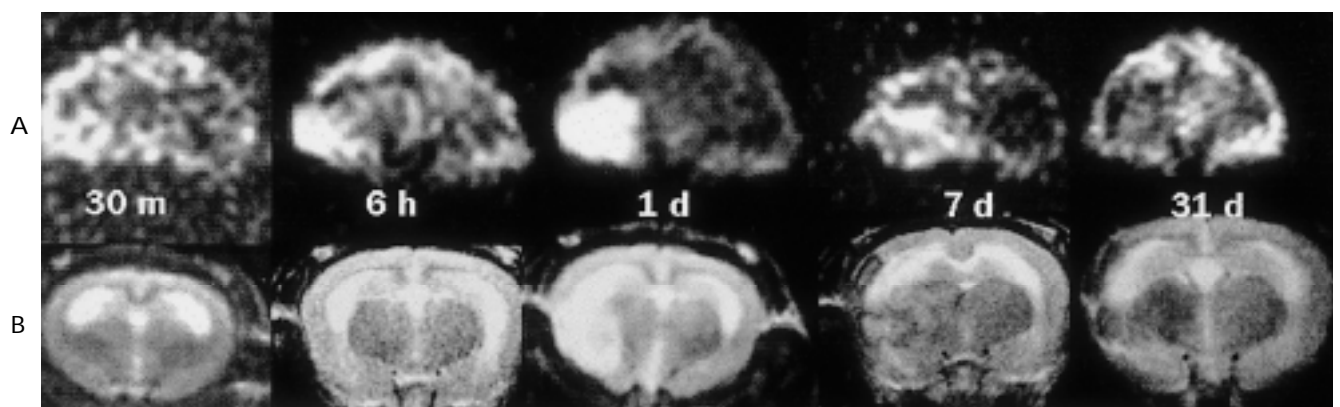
Serial diffusion-weighted (A) and T2-weighted images (B) after development of infarction.
